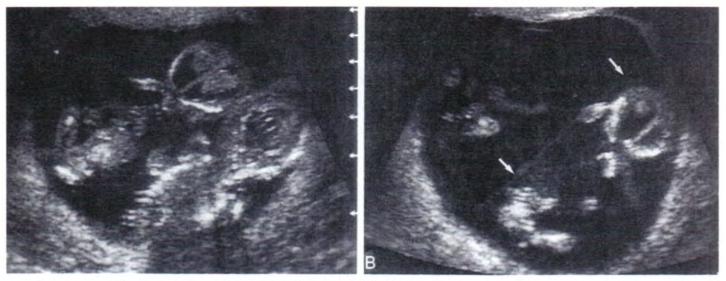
A. Transvaginal ultrasound image of monochorionic, diamniotic twins in a 12-week pregnancy. B. Arrows indicate diamniotic membrane.
